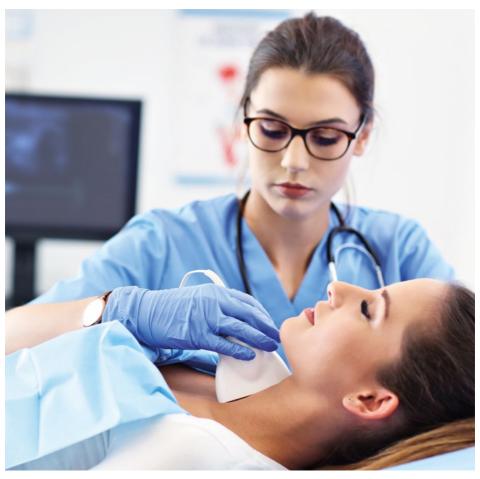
Carotid artery ultrasound
